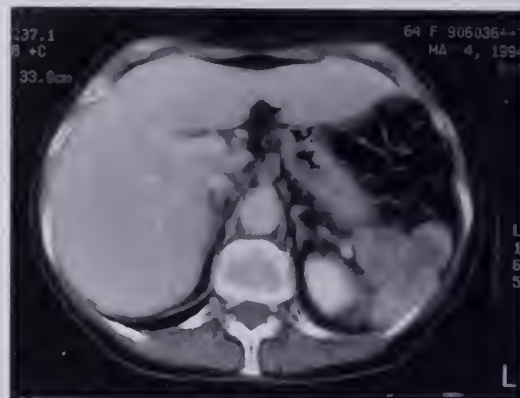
CT of the abdomen revealed a heterogeneously enhancing mass in the splenic hilum and along the inferior aspect of the spleen.
